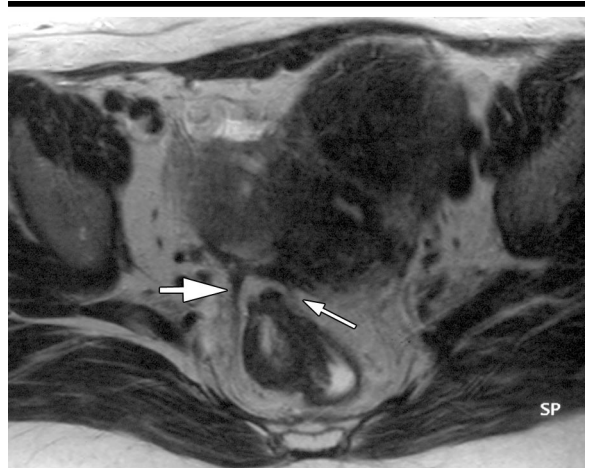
Transverse T2-weighted fast spin-echo MR image (4,500/128) demonstrates regular linear thickening of the right USL (thick arrow). Adipose tissue plane lying between uterus and rectum aids in ruling out intestinal involvement (thin arrow). True-positive diagnosis of linear uterosacral involvement with endometriosis was determined at MR imaging.
